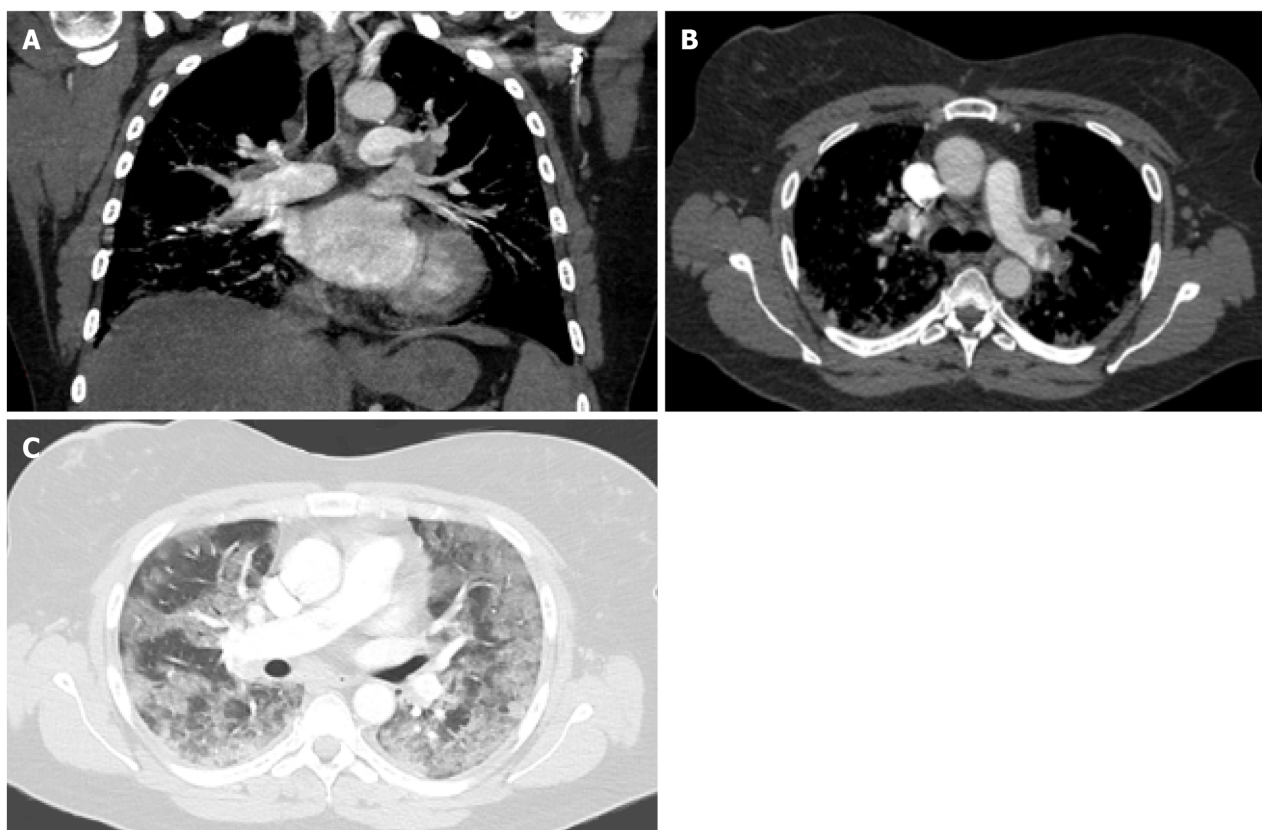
Pulmonary embolism. A-C: Coronal (A) and axial (B and C) images from a computed tomography angiography of the chest in a 53-year-old female with a history of chronic lymphocytic leukemia and asthma who was admitted for acute hypoxic respiratory failure secondary to coronavirus disease 2019 pneumonia, complicated by pulmonary emboli. A large filling defect is seen in the left pulmonary artery extending into lobar and segmental branches (A and B). Diffuse ground glass opacities are noted on the lungs bilaterally (C).
